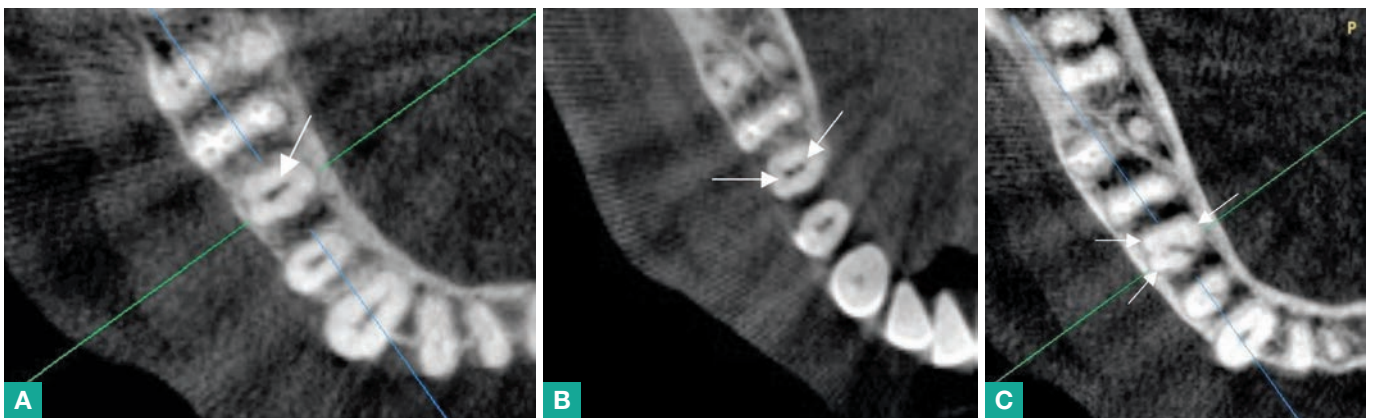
Enlarged axial section of CBCT images at three levels (a) coronal, (b) middle and (c) junction of middle and apical thirds of tooth 45, showing one, two and three canals respectively
